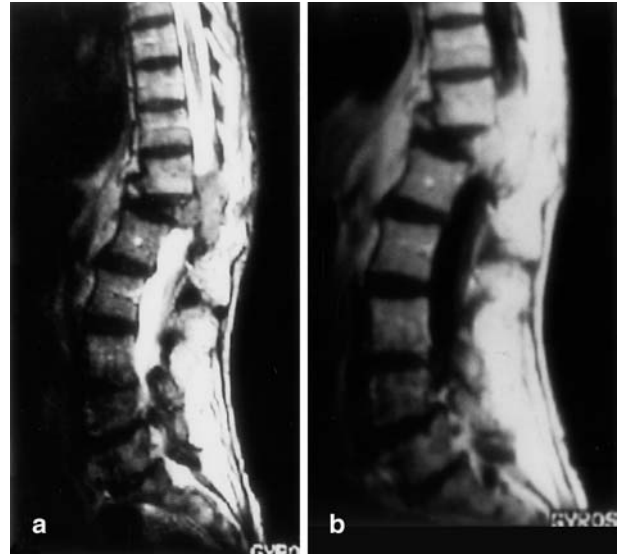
Plasmacytoma. a Sagittal T2-weighted and b sagittal post-contrast T1-weighted image show a severely collapsed T12 vertebra with low signal intensity and large soft tissue mass filling the spinal canal. Note the preservation of the adjacent intervertebral disks
